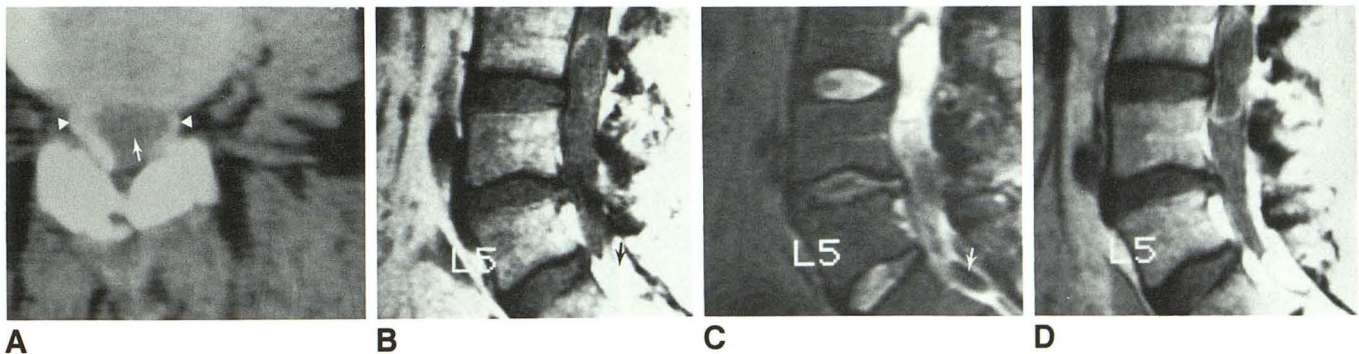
A, Axial CT through L3-L4 disk after intrathecal contrast administration shows intradural mass with density similar to CSF (arrow). Note contrast material around mass (arrowheads).
